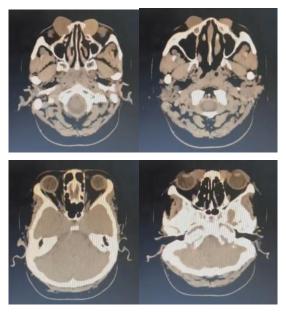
CT scan of the orbits with contrast
